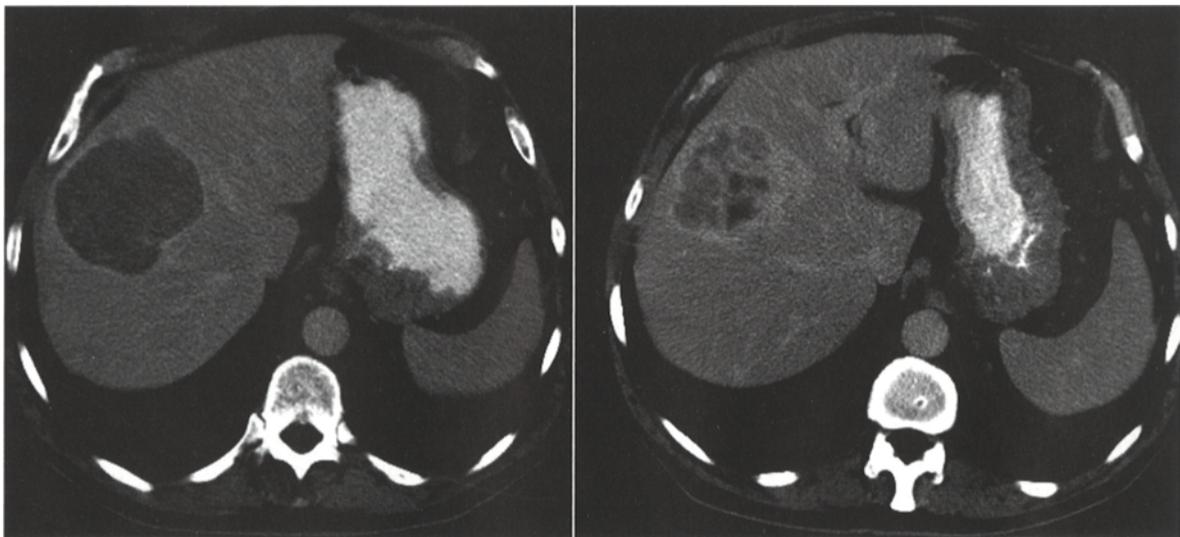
This patient is able to undergo the partition method activity calculation as the tumor volume can be clearly identified and measured in relation to lung and normal liver. Pre- and post-microsphere treatment CT scans show a significant response at 3 months. The partition model calculated a minimum dose to the tumor mass of 300 Gy. Ultimately the patient achieved a complete response by tumor marker and CT scan
